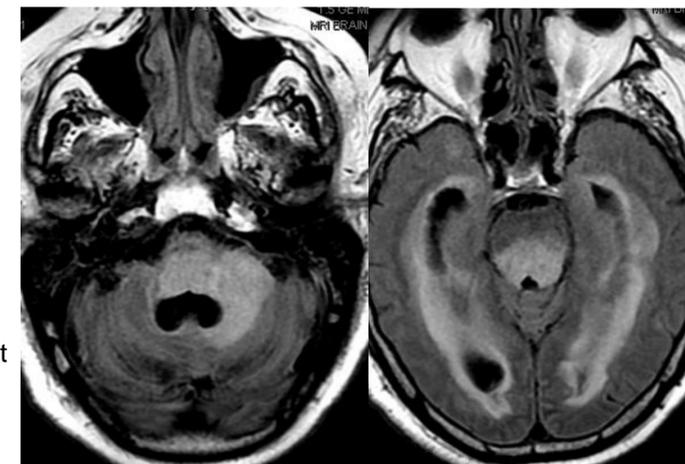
Brain MRI demonstrating findings consistent with multifocal ischemia.
